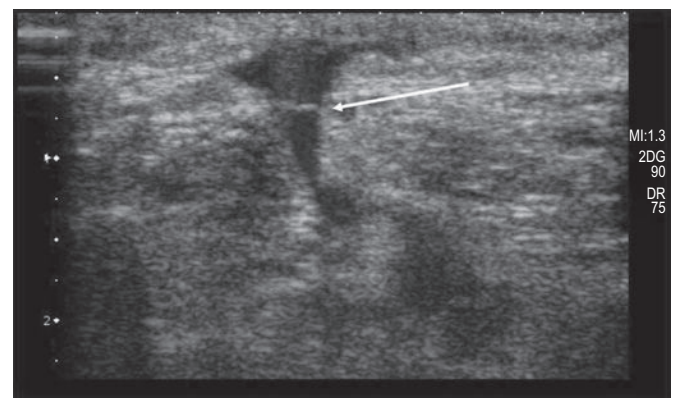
Perforating veins connect the superficial veins to the deep veins; they 'perforate' the aponeurotic fascia, giving them their name. The fascial point of perforation is always visible with ultrasound. Also, valves are visible, usually at the level of the fascial hole (arrow).
